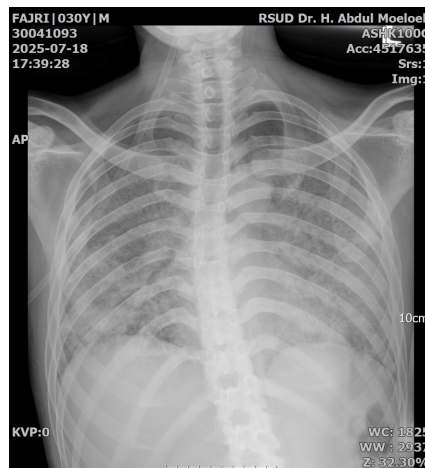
Chest X-ray examination
